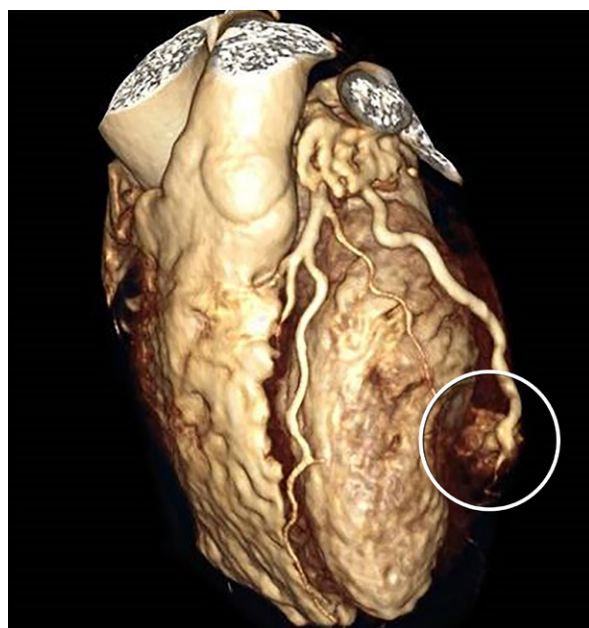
Computed tomographic coronary angiogram (3-dimensional reconstruction) shows that a marginal branch of the left circumflex coronary artery ends in the tumor (encircled), which is in the inferolateral wall of the left ventricle.
